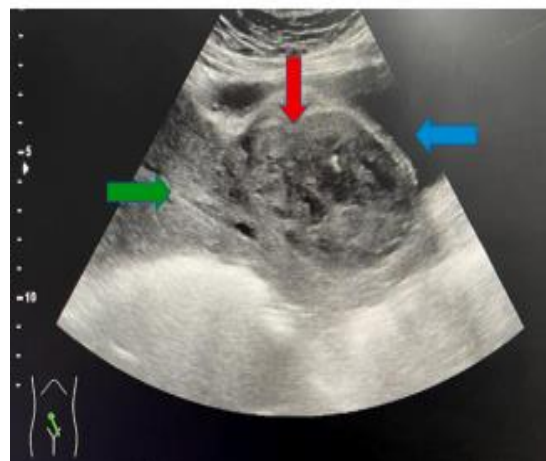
Ultrasonography Retzius space hematoma
